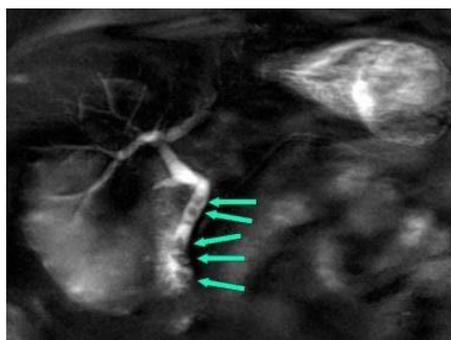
MRI in the diagnosis of cholelithiasis
